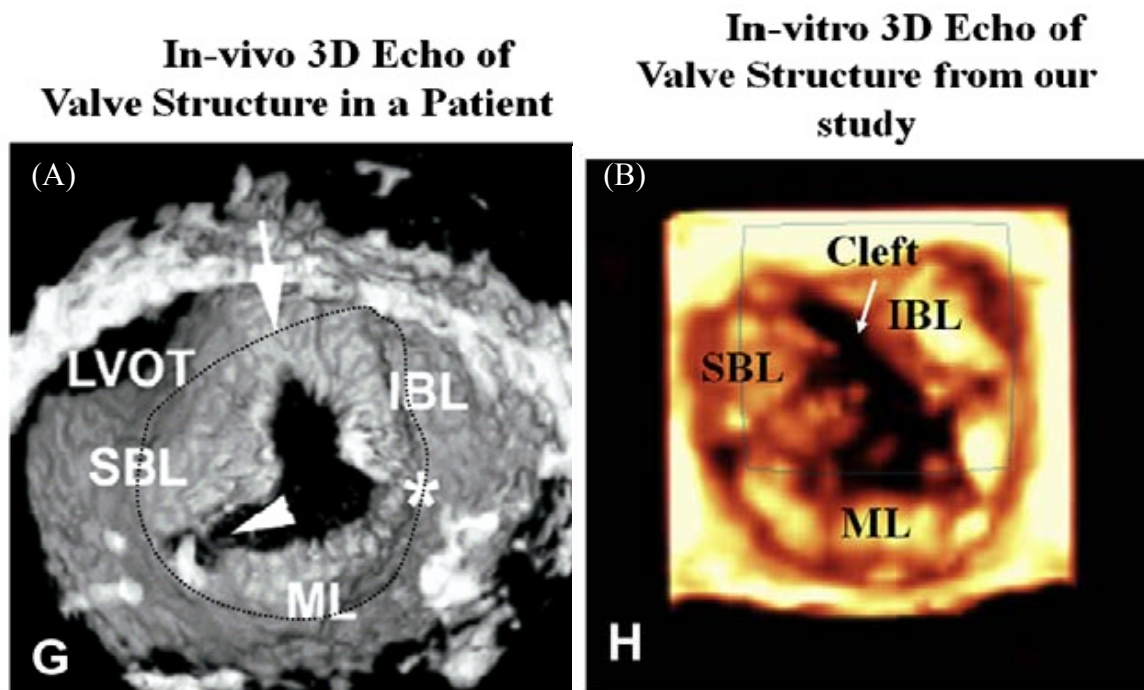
(A) In-vivo 3D echocardiograph of the mitral valve depicting the cleft in the anterior segment with the two bridging leaflets and a smaller posterior leaflet, (B) Shows an in vitro echocardiograph demonstrating the similarities between the two valves at systolic ejection with loss of coaptation between the opposing bridging leaflets and the mural leaflet. Image (A) reproduced from Takahashi et al. 2006. J Am Soc Echocardiography.
